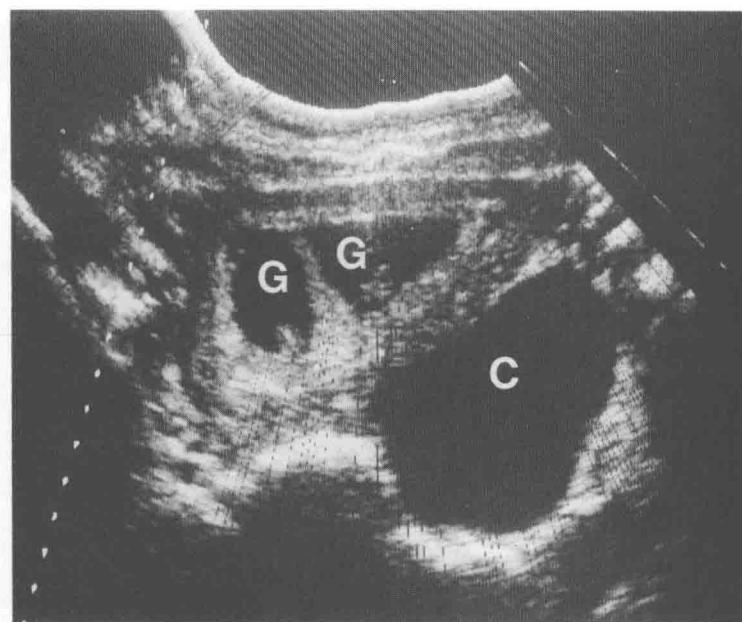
Transverse view of a uterus containing two gestational sacs (G) with a twin pregnancy. A large corpus luteum cyst (C) is present in the left adnexa. It disappeared on subsequent sonograms.
